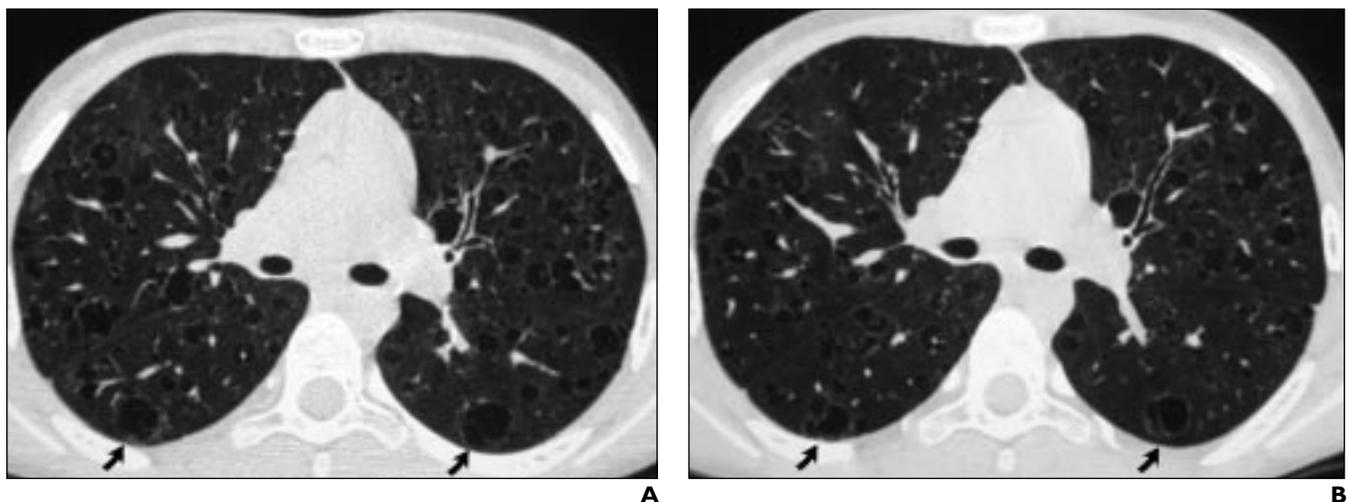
11-year-old boy with pulmonary histiocytosis X. A and B, High-resolution CT scans of chest obtained with 34 mAs (A) (average image quality score, 4.07) and 180 mAs (B) (average image quality score, 4.01) show widespread thin-walled, air-filled cysts (arrows). Fissures appear sharper in B than in A.
